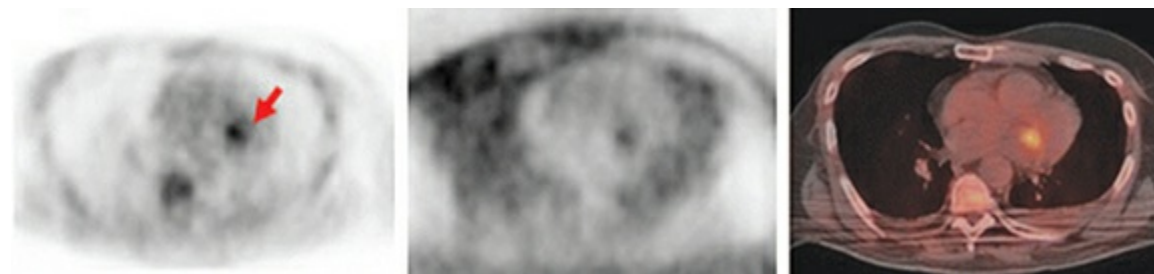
^{18}F -FDG positron emission tomography (PET)/computed tomography (CT) imaging of a case of suspected infective endocarditis. The increased ^{18}F -FDG activity (arrow) corresponds to an infected mitral valve. (Reproduced with permission from Kouijzer IJ, Vos FJ, Janssen MJ, et al. The value of ^{18}F -FDG PET/CT in diagnosing infectious endocarditis, *Eur J Nucl Med Mol Imaging*. 2013 Jul;40(7):1102-1107.)
